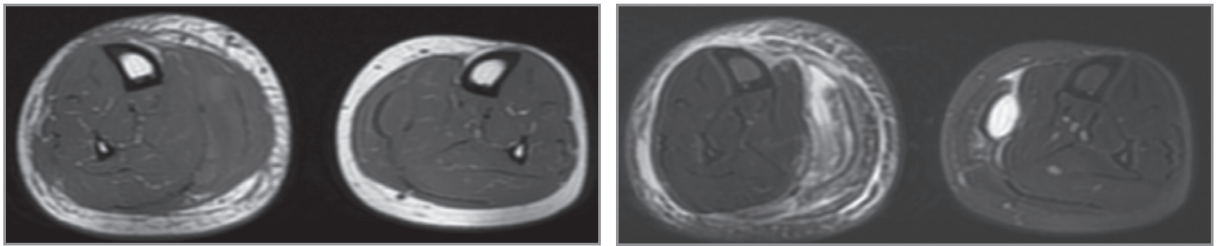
Axial T1 spin fast echo (FSE) and T2 weighted fat sat (FS) magnetic resonance images of the same pathologies mentioned for the coronal images.
